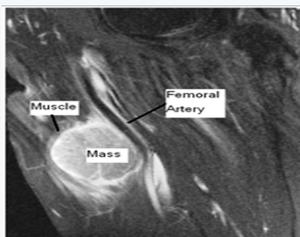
MRI T1 sagittal view showing mass close to femoral vessels.
